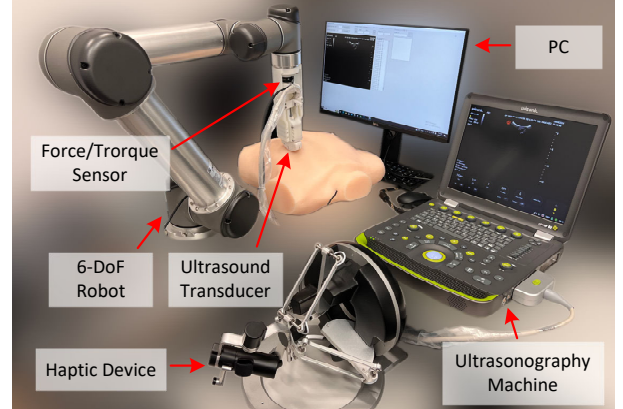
The presented system comprises a ultrasonography machine (Wisonic Clover 60) for ultrasound image acquisition, a 6-DoF manipulator (Universal Robots UR5) for maneuvering the ultrasound transducer, a 6-axis force/torque sensor (Sunrise Instruments M3733C) mounted on the robot end flange for measuring the robot-patient contact wrench, a 7-DoF haptic device (Force Dimension omega.7) for teleoperation and a PC (ROS Humble) running the essential system software.
